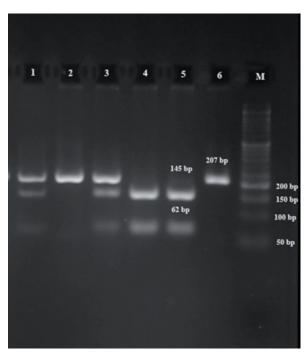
PCR-RFLP patterns of the MDR1 3435C>T with Mbo I. 1 and 3 lanes: CT genotype (heterozygous samples); 2 and 6 lanes: TT genotype; 4 and 5 lanes: CC genotype; and M: Ladder 50 bp.
